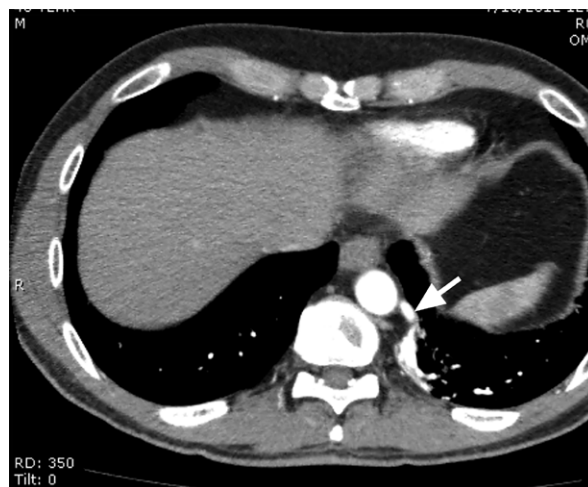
Patient 2. Computed tomographic angiogram shows that the arterial supply (arrow) of the extralobar pulmonary sequestrum arises from the descending thoracic aorta.
